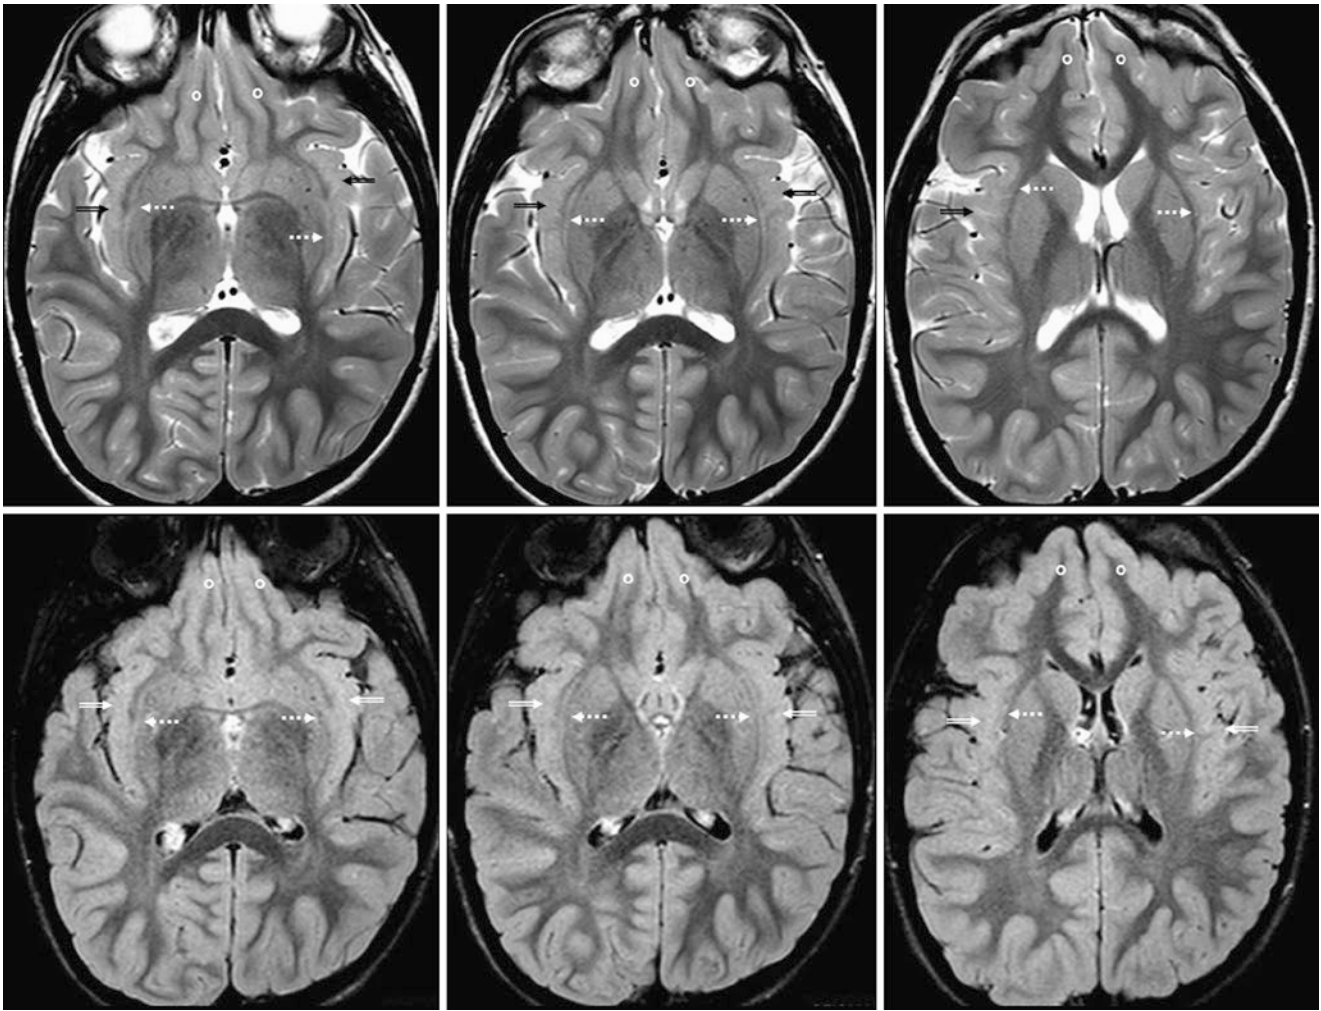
A 5.25-year-old with headaches. 3T MRI axial SE T2WI (top row) and 3D FLAIR (bottom row) were normal. Note SIWM terminal zones (beveled arrows) bilaterally, being only mildly hyperintense on both sequences. Meanwhile, the subjacent claustrum is visible (dotted arrows). This shows that SIWM terminal zones can overlap with the normal claustrum and in some cases may be “volume averaged” with the developing claustrum. Also, note mature OFWM (circles) anteriorly
